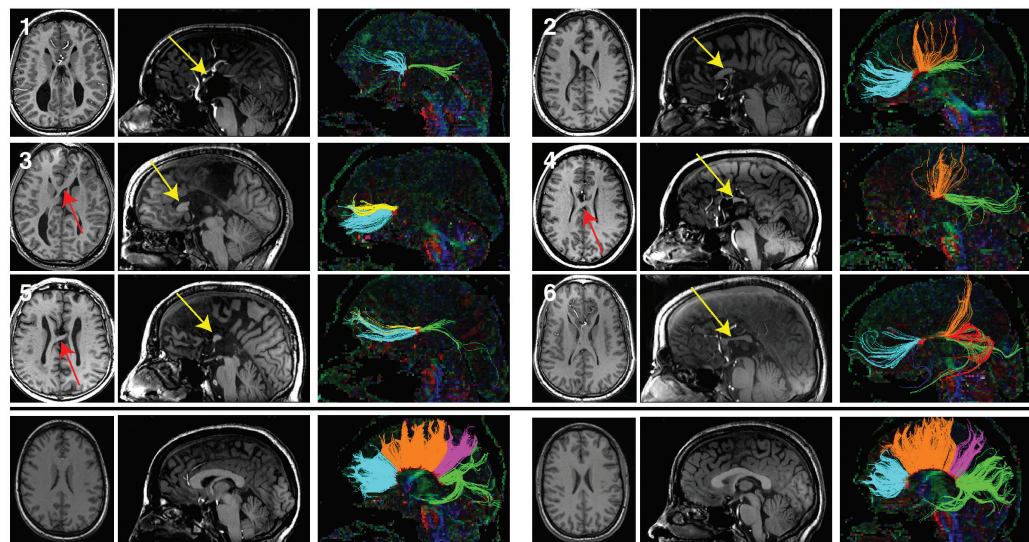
Tractography studies in patients with partial agenesis of the corpus callosum (pACC). T1-weighted anatomic images and DTI tractography of six subjects with pACC (*top panels*) and two representative controls (*bottom panel*). Axial (*left*) and midline sagittal (*middle*) T1 sections are shown for each subject. Callosal fragments are identified with yellow arrows, and heterotopic fibers visible on T1-weighted images are denoted by red arrows. Midline sagittal DTI color maps are shown with segmented callosal fibers (*right*). For subjects with pACC, connectivity ranged from anterior frontal connections (subject 3) to only posterior frontal and occipitotemporal connections (subject 4). One individual (subject 5) displayed a discontinuous set of homotopic callosal connections, with anterior frontal and occipitotemporal connectivity without any posterior frontal or parietal connections. Control subjects (*bottom panel*) display normal callosal morphology and tractography results. Tracts are segmented and colored according to their cortical projections: homotopic anterior frontal, blue; homotopic posterior frontal, orange; homotopic parietal, pink; homotopic occipitotemporal, green; heterotopic left anterior-right posterior, yellow; heterotopic right anterior-left posterior, red. (Reprinted, with permission, from Wahl et al. 2009 [© AJNR].)
